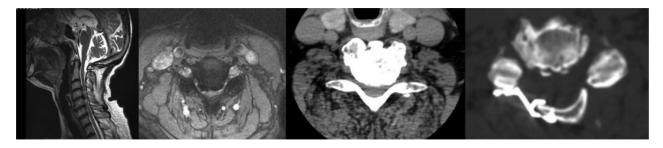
Laminoplasty A patient with cervical stenosis and myelopathy treated with laminoplasty: preop MRI and pre- and postop CT scan images.
